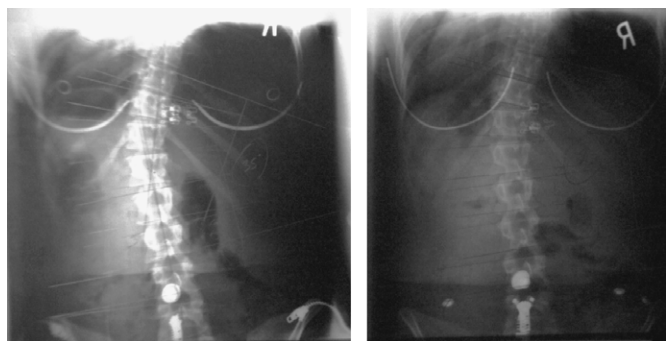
Initial standing AP radiographic examination: 35° left convex thoracolumbar scoliosis
